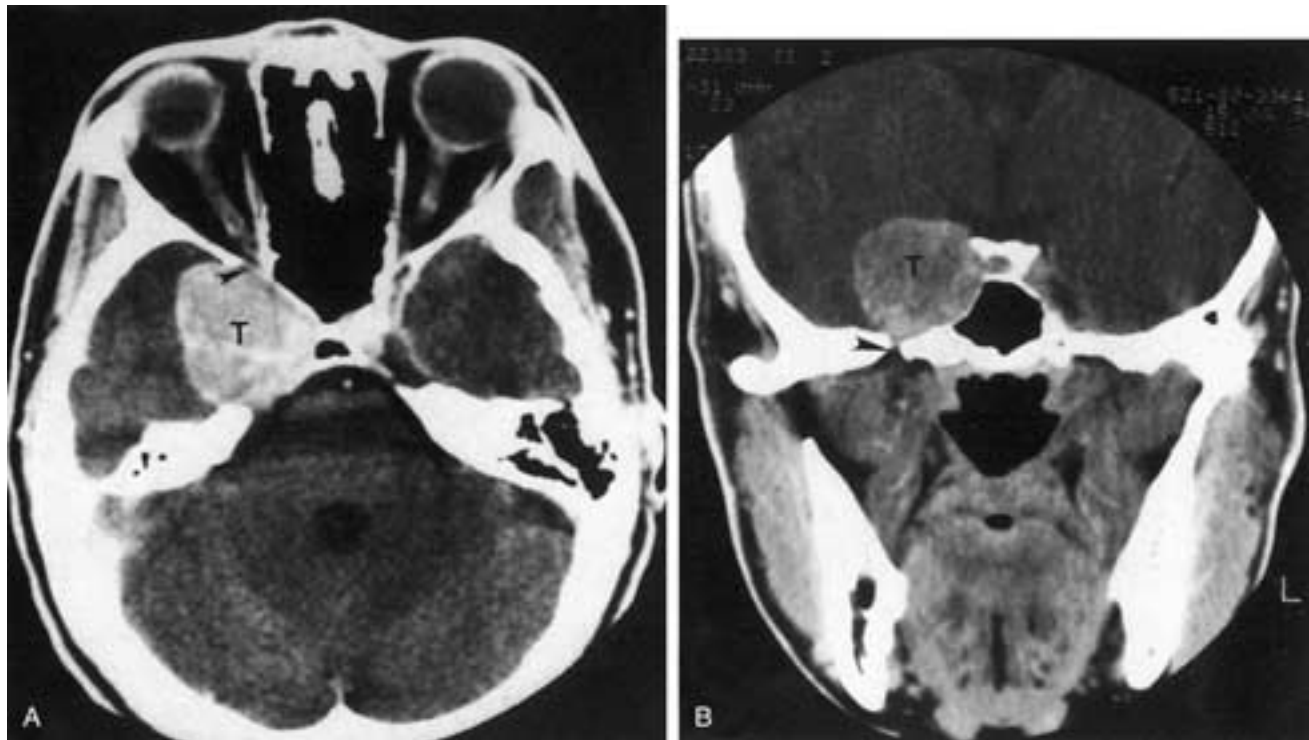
Neuroma of the cavernous sinus area. CT scan with contrast enhancement. A, Axial scan. The tumor (*T*) is seen at the level of the superior orbital fissure. The tumor bulges into and compresses the fat in the superior orbital fissure (*black arrowhead*) but does not protrude into the orbit. B, Coronal scan shows the tumor (*T*) scalloping and eroding the sphenoid sinus and dorsum sellae. Again, it extends to but not through the foramen ovale. Note the maintenance of the normal fat (*black arrowhead*) just beneath foramen ovale.
